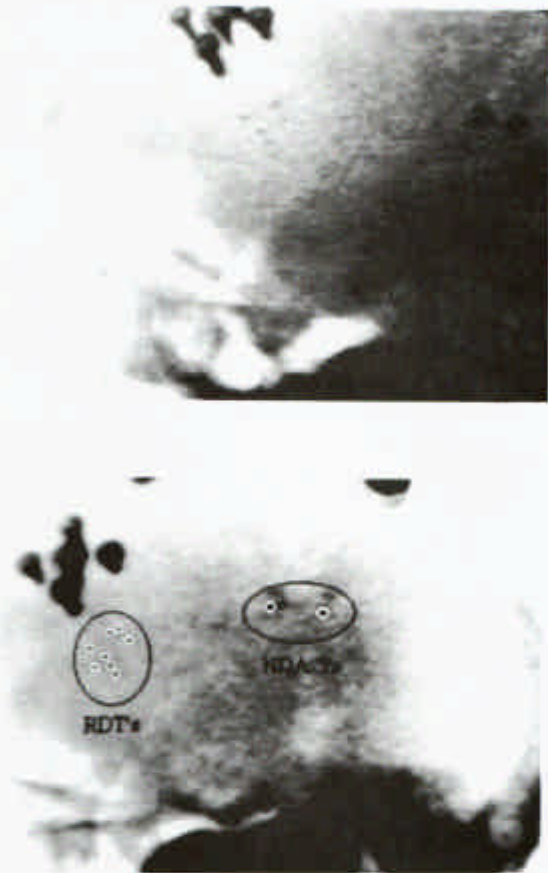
Figure #11a-b: High-speed video images of x-ray image-intensifier output. Pre-impact, unprocessed (a, top), and during impact, processed (b, bottom).
